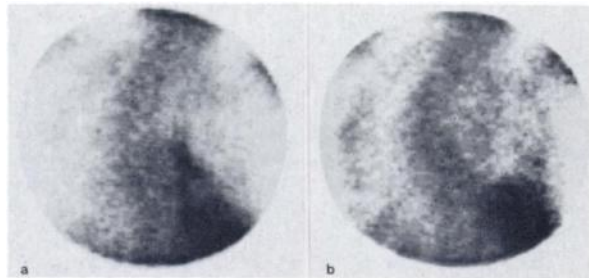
Case 3: Posterior Ga-67 lung scintigram (note marked scoliosis); (a) intense Ga-67 activity in R lower field above liver while on amiodarone; quantitative uptake elsewhere in lungs slightly increased; (b) disappearance of lesion after withdrawal, with some residual activity at right base; normalization of quantitative values in rest of lungs.
